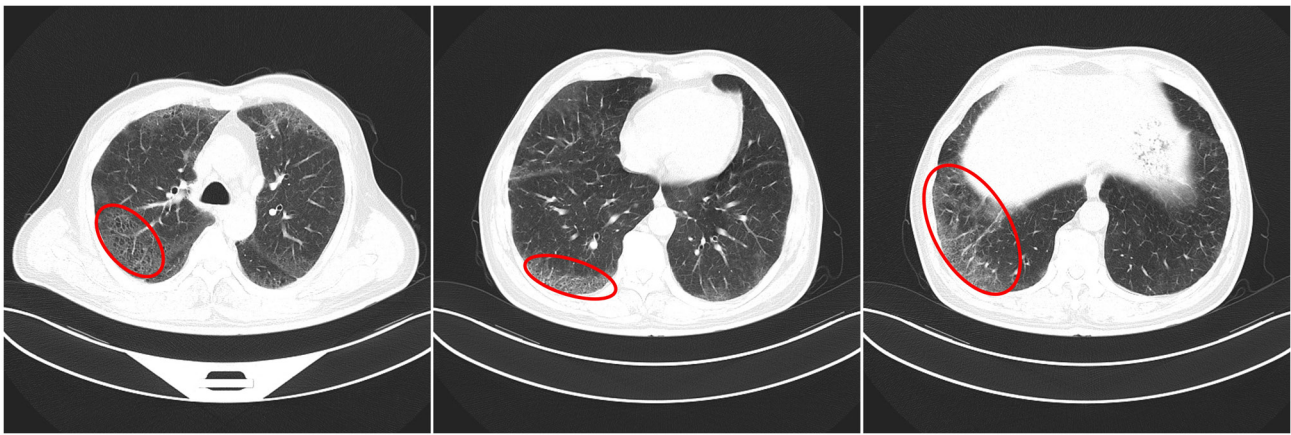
Chest CT indicating multiple ground glass shadows in both lungs and some cysts were found (lesion sites are circled in red; June 2019).
